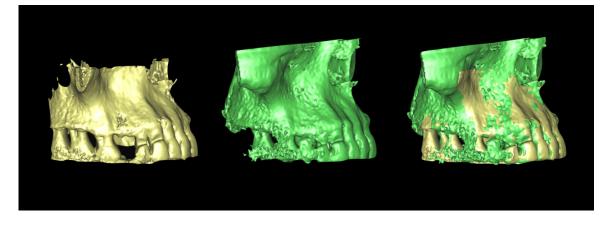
Using anatomic structures as reference, a CBCT taken after tooth extraction (yellow) and a CBCT taken several months after ridge preservation (green) can be superposed and compared.
